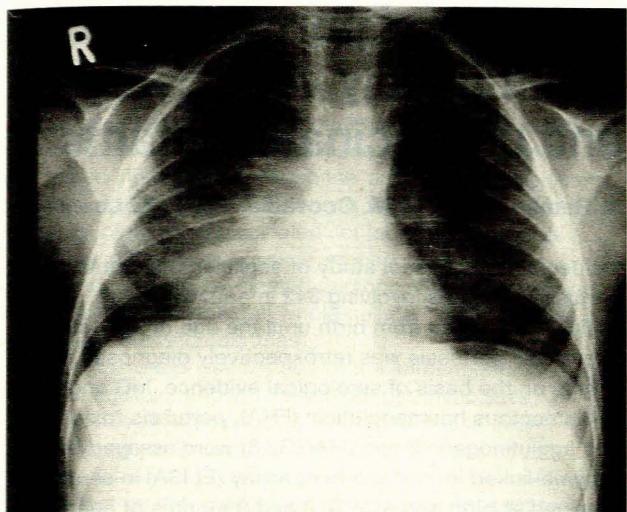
Chest radiograph (above) and CT scan (below) of a boy with unilateral pulmonary hypoplasia (arrow).
